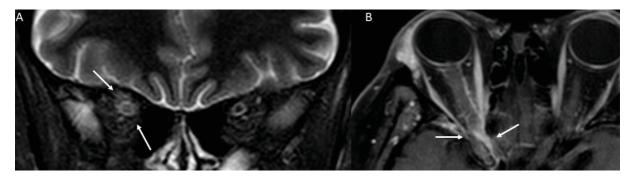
Patient 1. MRI. A. STIR sequence in coronal plane showing hiperintense signal in the orbital fat surrounding optic nerve sheath (arrows). B. Post contrast T1 sequence in axial plane depicting abnormal enhancement adjacent to optic nerve at the level of the optic canal (arrows).
